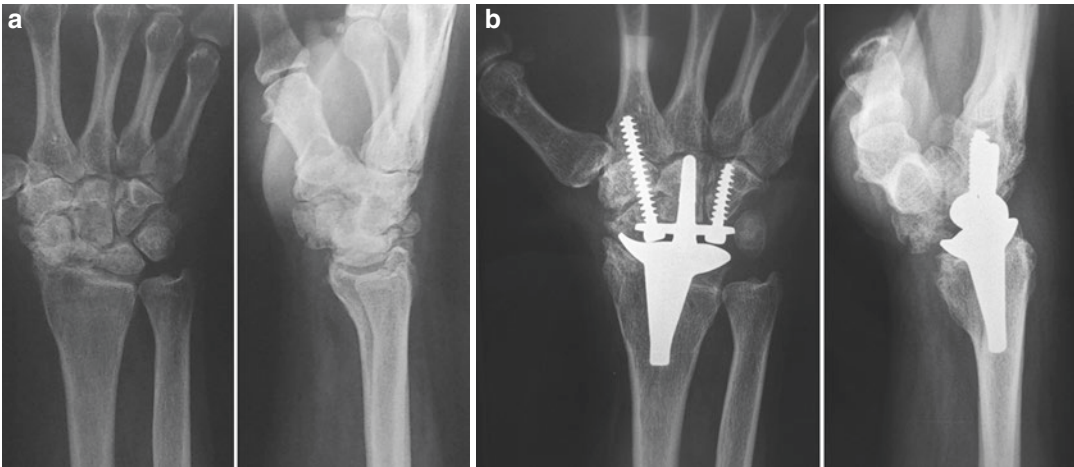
(a) SNAC wrist stage III in a 47-year-old male patient. Note pan-carpal OA (b) ReMotion total wrist replacement. Postoperative X-rays at a 4-year FU
